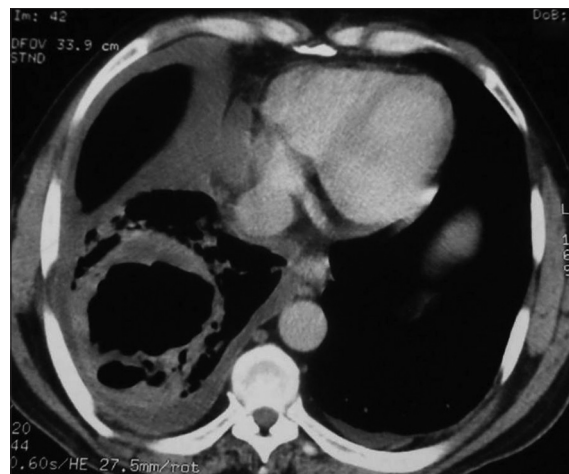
CT: Cavitory lesion measuring 7.5 × 7 cm, involving right lower lobe surrounded by parenchymal condensation and right pleural effusion
